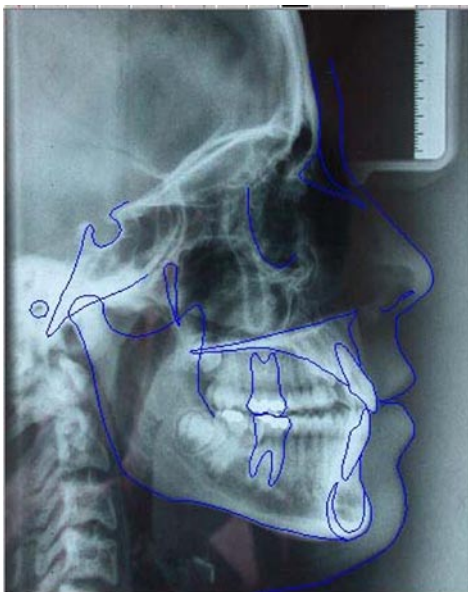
Digital Lateral measured radiography.
